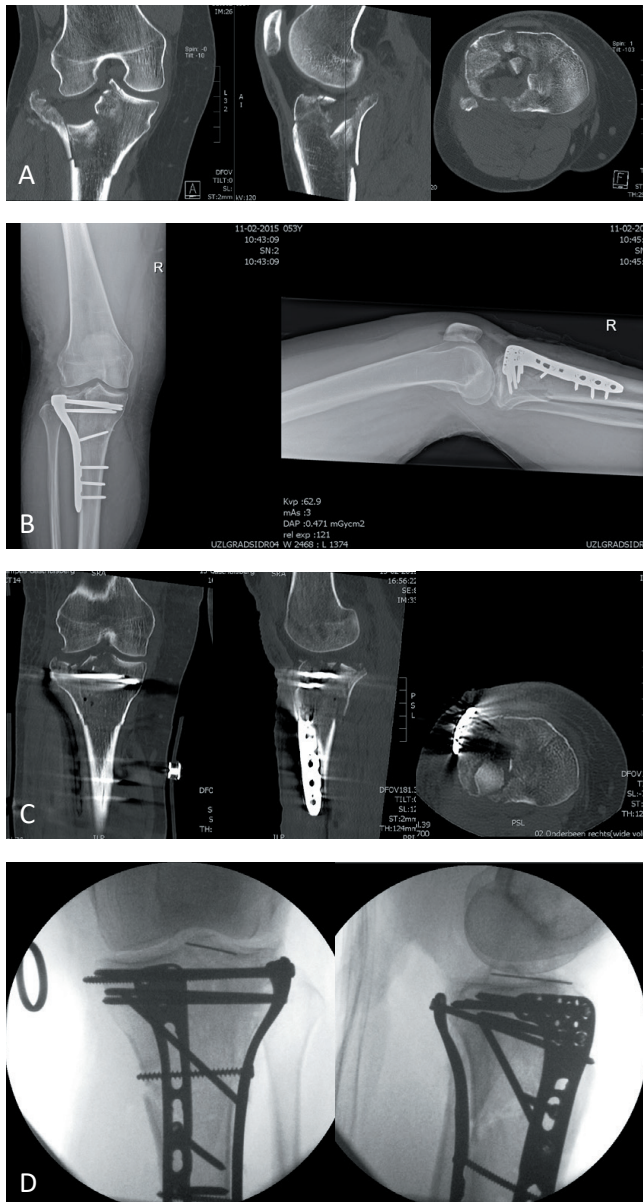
53-year-old female who sustained a three-column tibial plateau fracture. A, preoperative CT including respectively coronal, sagittal and axial view. B, initial treatment consisted of a single VA-LCP osteosynthesis. C, postoperative CT revealed coronal and sagittal malalignment due to a collapsed lateral tibial plateau and an unstable posterior column fracture (respectively coronal, sagittal and axial view). D, reosteosynthesis with posterior buttress of the posterior column fracture and ORIF of the extended lateral column using a VA-LCP and a K-wire. The combined (antero-) lateral and posteromedial reversed L-shaped approach provide here an extensive exposure of both the joint (whole extended lateral column) as well as the posterior aspect of the proximal tibia. After arthrotomy and tibia condyle osteotomy, the exposure of the joint can be increased by inserting a small retractor behind the posterior wall just medially of the fibular head.
